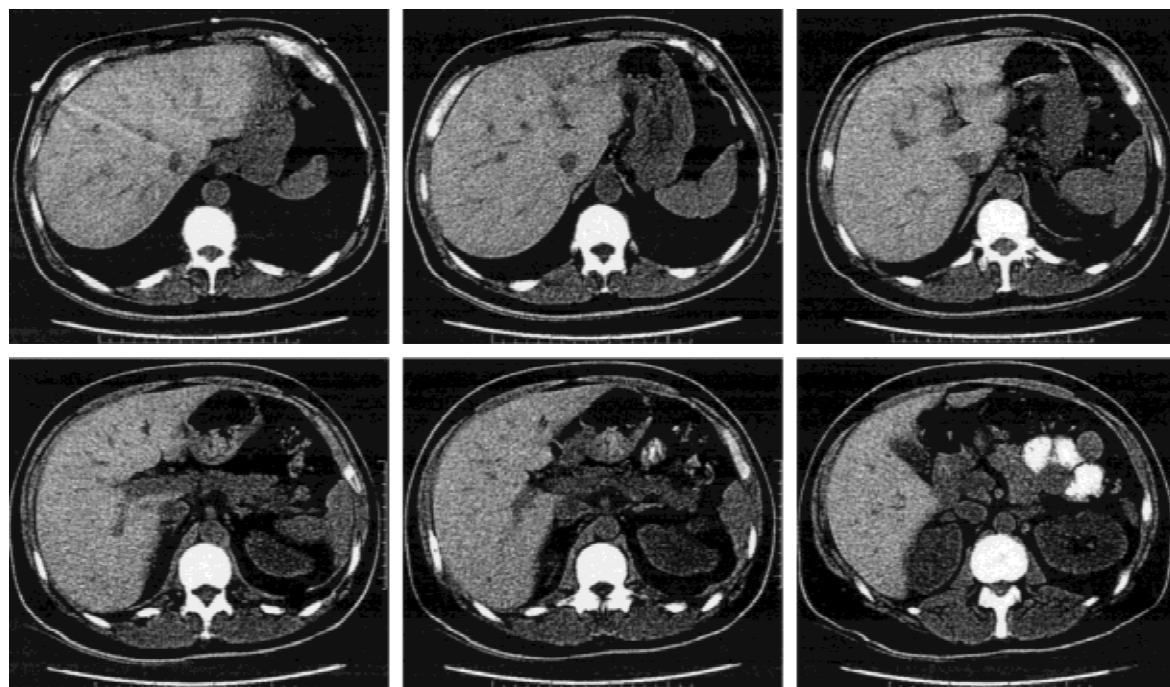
Abdominal computed tomographic scan showing a normal pancreas and a nonspecific, homogeneously slightly increased density found throughout the liver.
